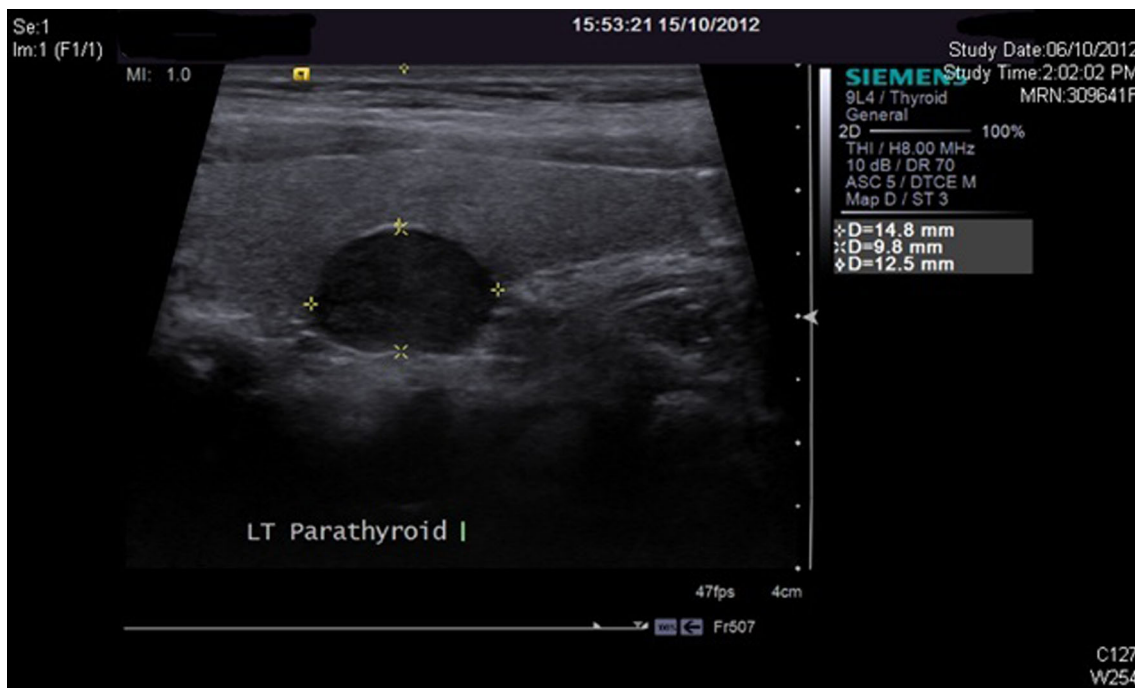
Ultrasonography of neck showed a 14.8 mm × 12.5 mm × 9.8 mm hypoechoic solid lesion posterior to left lobe of thyroid
